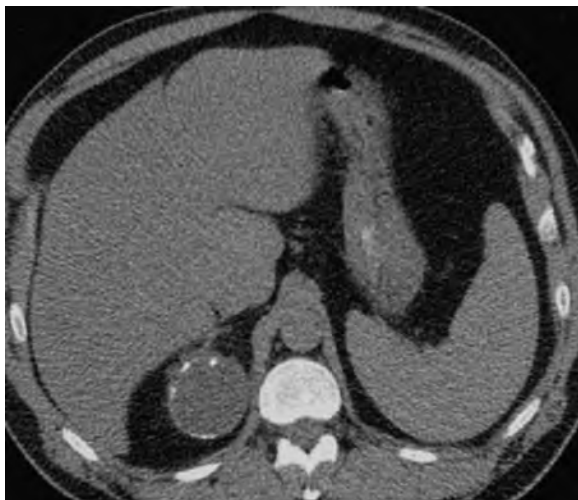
Unenhanced computed tomography scan of a right adrenal cyst. Stippled calcifications within the cyst wall are not unusual in these lesions, as can be seen in this particular lesion.
